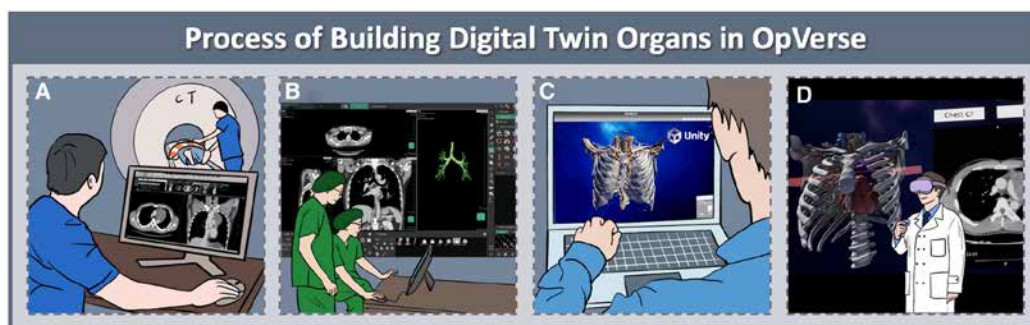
Process of building digital twin organs in OpVerse. (A) Acquisition of high-resolution patient CT data in DICOM format. (B) Reconstruction of a 3D digital model from the CT data using specialized software. (C) Creation of an immersive VR environment within the Unity platform. (D) Manipulation and observation of the patient's digital twin thoracic model in the VR world using a head-mounted display. 3D: three-dimensional; CT: computed tomography; DICOM: digital imaging and communications in medicine; VR: virtual reality.
